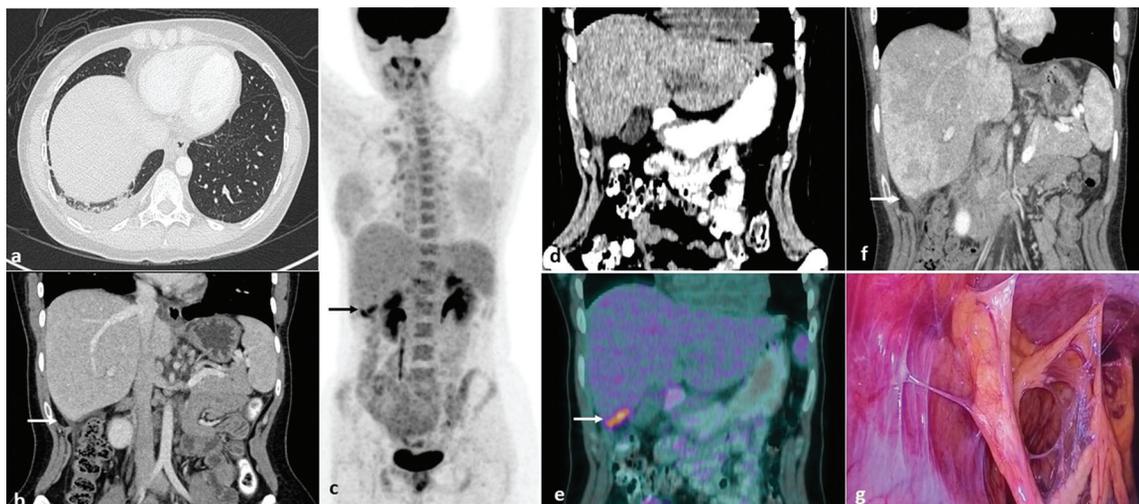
(A, B) Axial CT showed minimal opacities with pleural changes at right lower lung base and no significant abnormalities in the abdomen. (C) PET MIP images revealed curvilinear hypermetabolism at the sub-hepatic region. (D, E) Axial CT and fused PET-CT showed sub-hepatic hypermetabolic focus corresponded to subtle sub-hepatic density. (F) 5-month follow-up axial CT showed mild worsening of the sub-hepatic density. (G) Diagnostic laparoscopy revealed violin string-like adhesions at supracolic compartment involving the liver, gallbladder, duodenum, and surrounding omentum.
